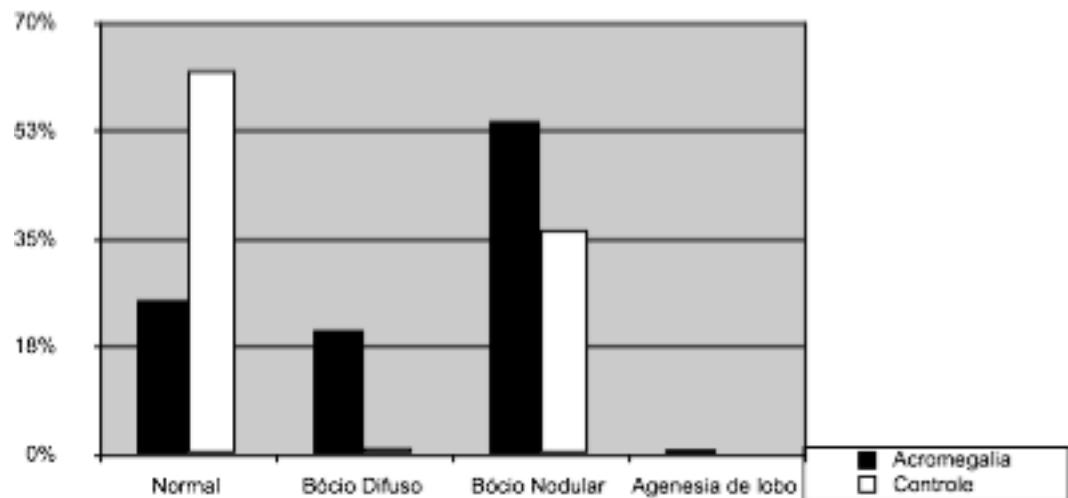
Achados na ultrassonografia de tireoide (n=387)
